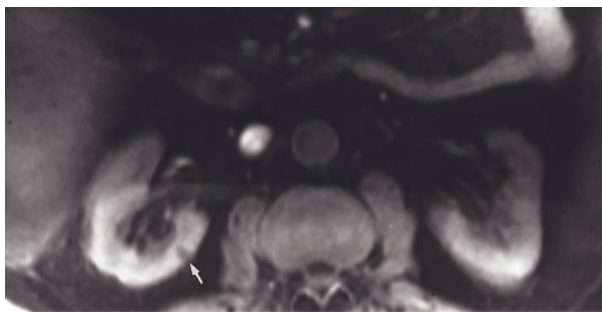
Small angiomyolipoma. T1-weighted precontrast SGE (a) and precontrast fat-suppressed SE (b) images. A small high-signal-intensity lesion arises from the upper pole of the right kidney on the SGE image (arrow, a). Fat suppression decreases the signal intensity of this lesion (arrow, b), confirming that it represents an angiomyolipoma. T1-weighted precontrast in-phase (c) and out-of-phase (d) SGE and 90-s fat-suppressed gadolinium-enhanced SGE (e) images in a second patient demonstrate a high-signal-intensity tumor on the in-phase image (arrow, c) that becomes signal void on the out-of-phase image (d) because of phase-cancellation artifact. The lesion is very low in signal on the postgadolinium fat-suppressed image (e). T1-weighted precontrast
